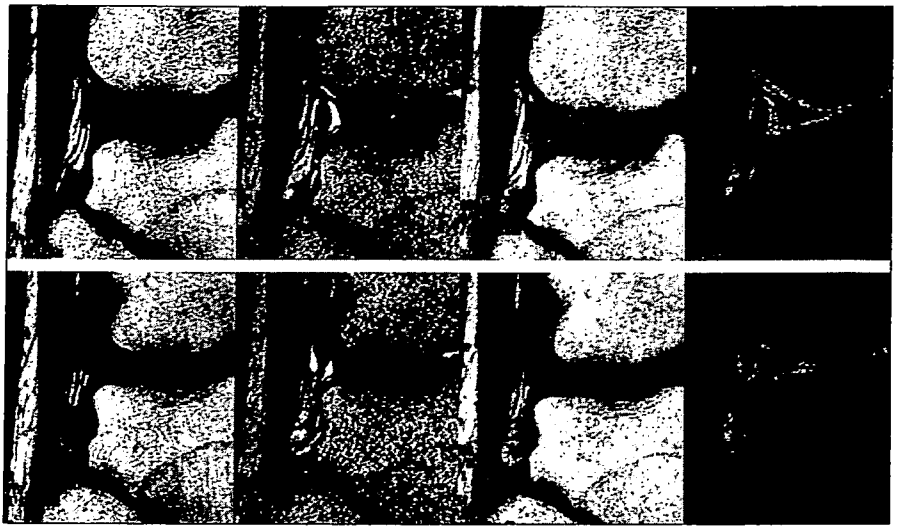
Effects of MRI sequence for depicting popliteomeniscal fasciculi (PMF). Four sets of sequences were applied for depicting PMF. From left column to right: T1-weighted, T2-weighted, proton density-weighted, and proton fat-saturation images. Posteriosuperior fasciculi are depicted in upper four images and anteroinferior fasciculi are depicted in lower four.
